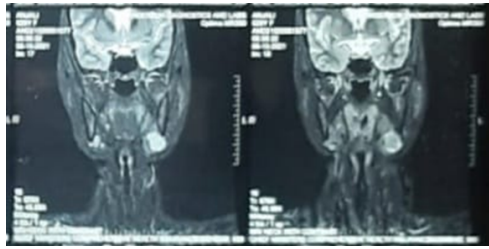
MRI Neck coronal view showing hetero-intense left submandibular gland mass- suggestive of pleomorphic adenoma of left submandibular gland.
